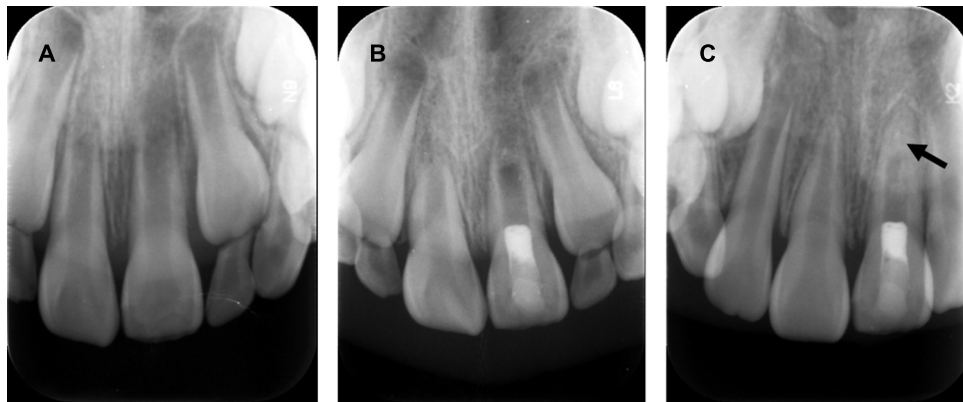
Revascularization promotes continued root development and resolution of periapical lesion, but disorganized radio-opaque changes occur within the apical root canal. (A) Radiograph of a maxillary left central incisor: immature root formation with a wide-open apex and periapical lesion. (B) Postoperative radiograph of revascularization and coronal restoration. (C) Radiograph of one-year follow-up: resolution of periapical lesion and root apex closure. Arrow: non-specific radio-opaque calcific deposit within apical root canal. Courtesy of Dr. Xin Zhou.
